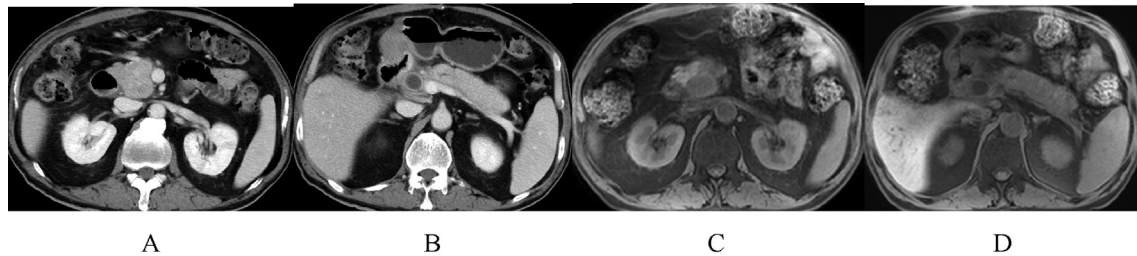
M/63. Diffuse AIP in body and tail combined with focal lesion in head. Venous phase CT image showed uniform enhanced lesion in head (A) and diffuse enlargement in body and tail (B). MR FS T1WI showed lightly hypointensity lesions in head (C) and body and tail (D).
